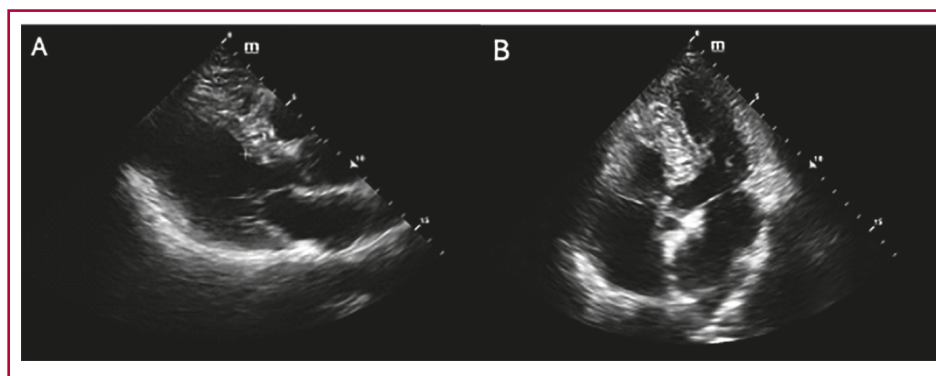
Transthoracic echocardiogram. A) long axis view and B) 4-chamber-view, showing increased interventricular septum thickness.
